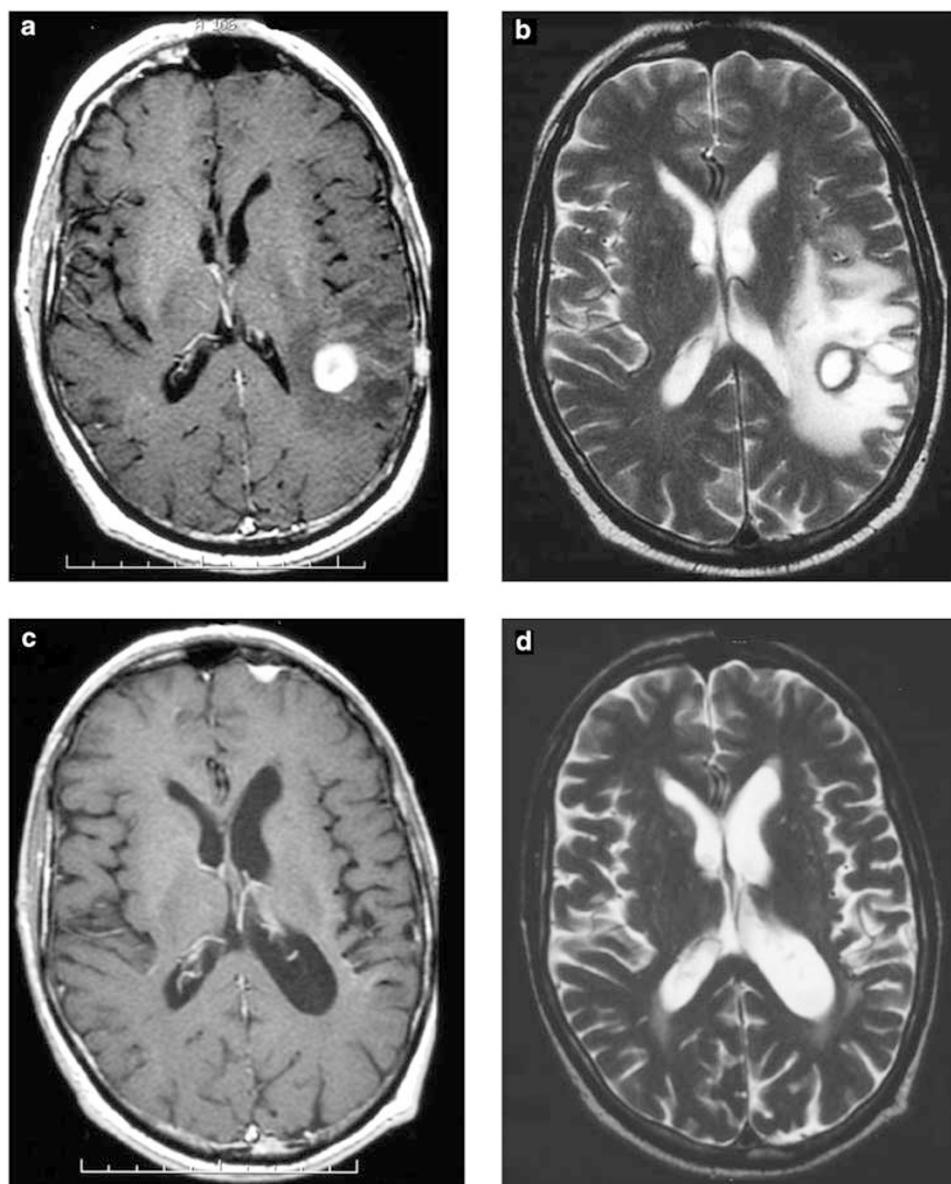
Brain MRI scans for patient #5, immediately before and 20 months after TBC/ASCT. Brain MRI after HDMTX/Ara-C induction chemotherapy and prior to TBC/ASCT: (a) T1 and (b) T2 weighted images. Brain MRI 20 months after TBC/ASCT: (c) T1 and (d) T2 weighted images.
